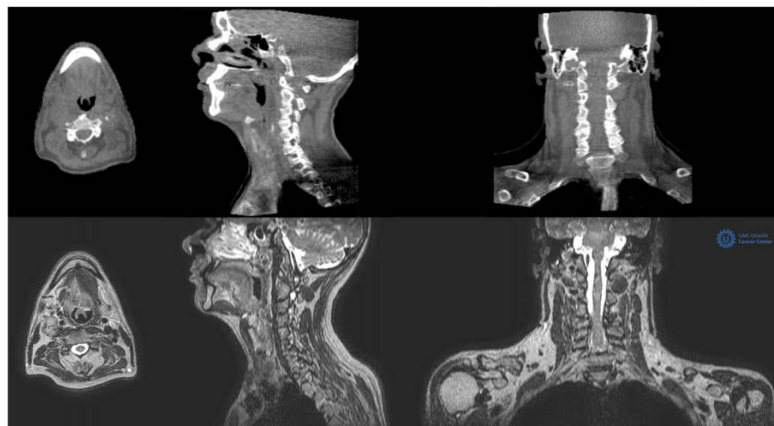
2: Cone beam CT images of an oropharyngeal cancer patient (top) compared to the 1.5 T MR images (T1) of the same patient acquired at the MRL (bottom).
